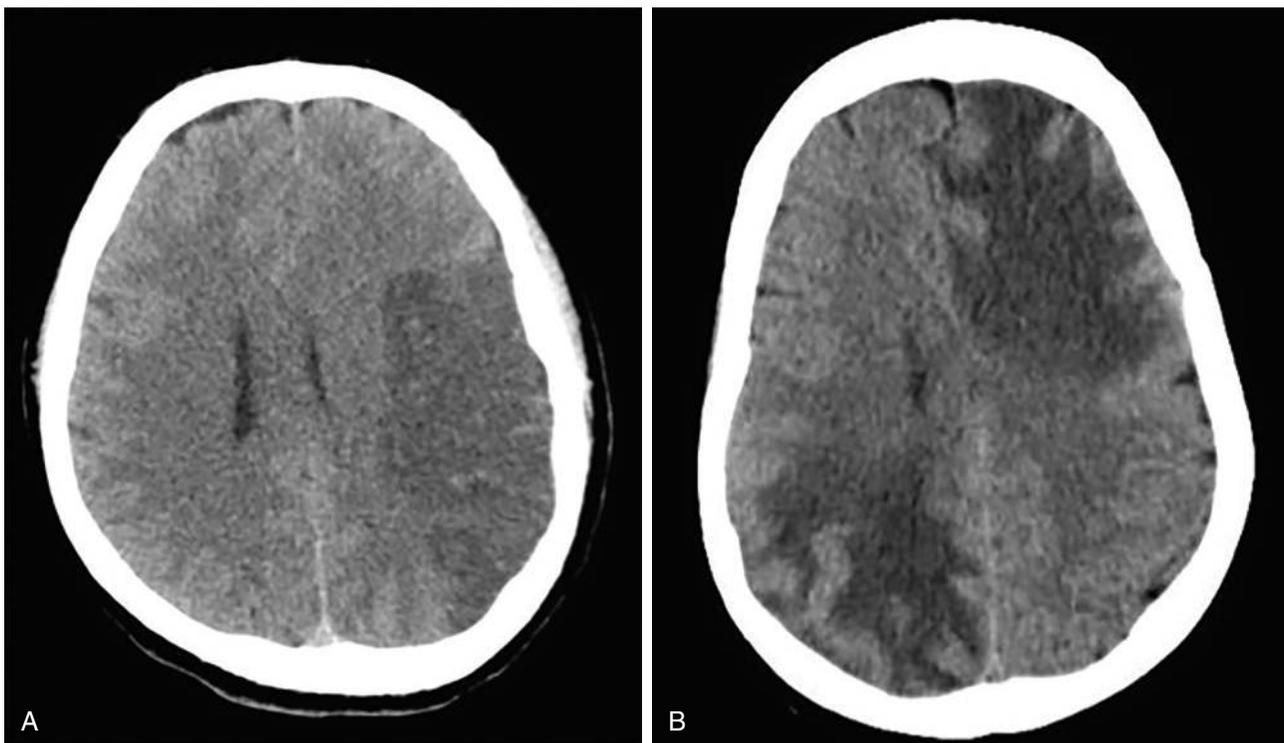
Cytotoxic versus vasogenic edema. A, Noncontrast CT in this patient with left middle cerebral artery territory infarction shows cytotoxic edema as a region of hypoattenuation involving the cortex and adjacent white matter with effacement of the sulci. B, Vasogenic edema in a patient with metastatic disease presents as white matter-predominant hypoattenuation with relative sparing of the overlying cortex.
